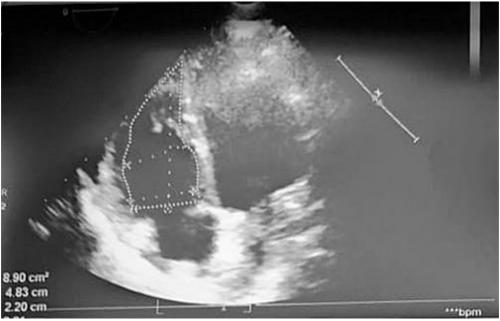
Echocardiography 1 month follow up had showing the size and density echogenic mass reduction
